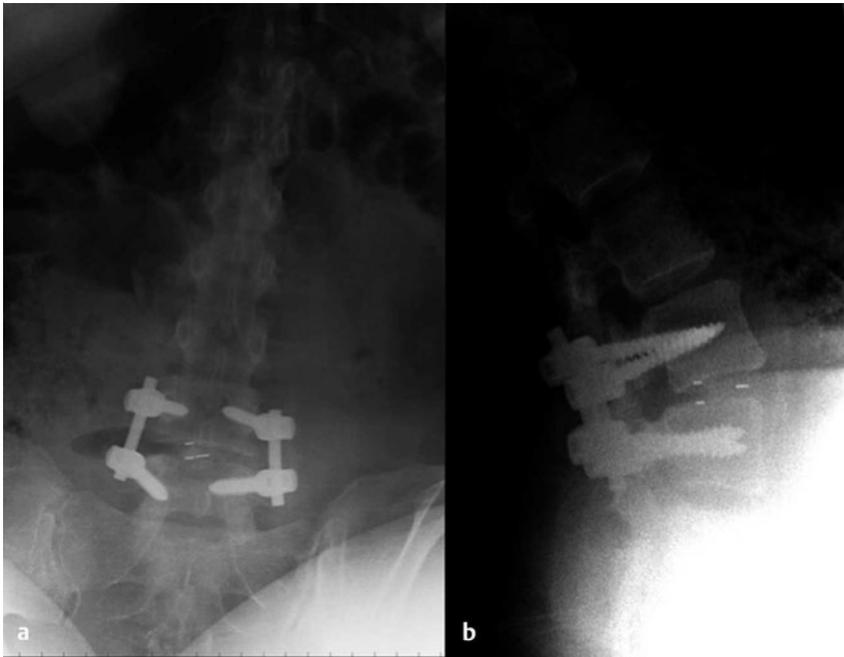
(a,b) Postoperative radiographs showing reduction of a spondylolisthesis from a transforaminal interbody fusion (TLIF).
